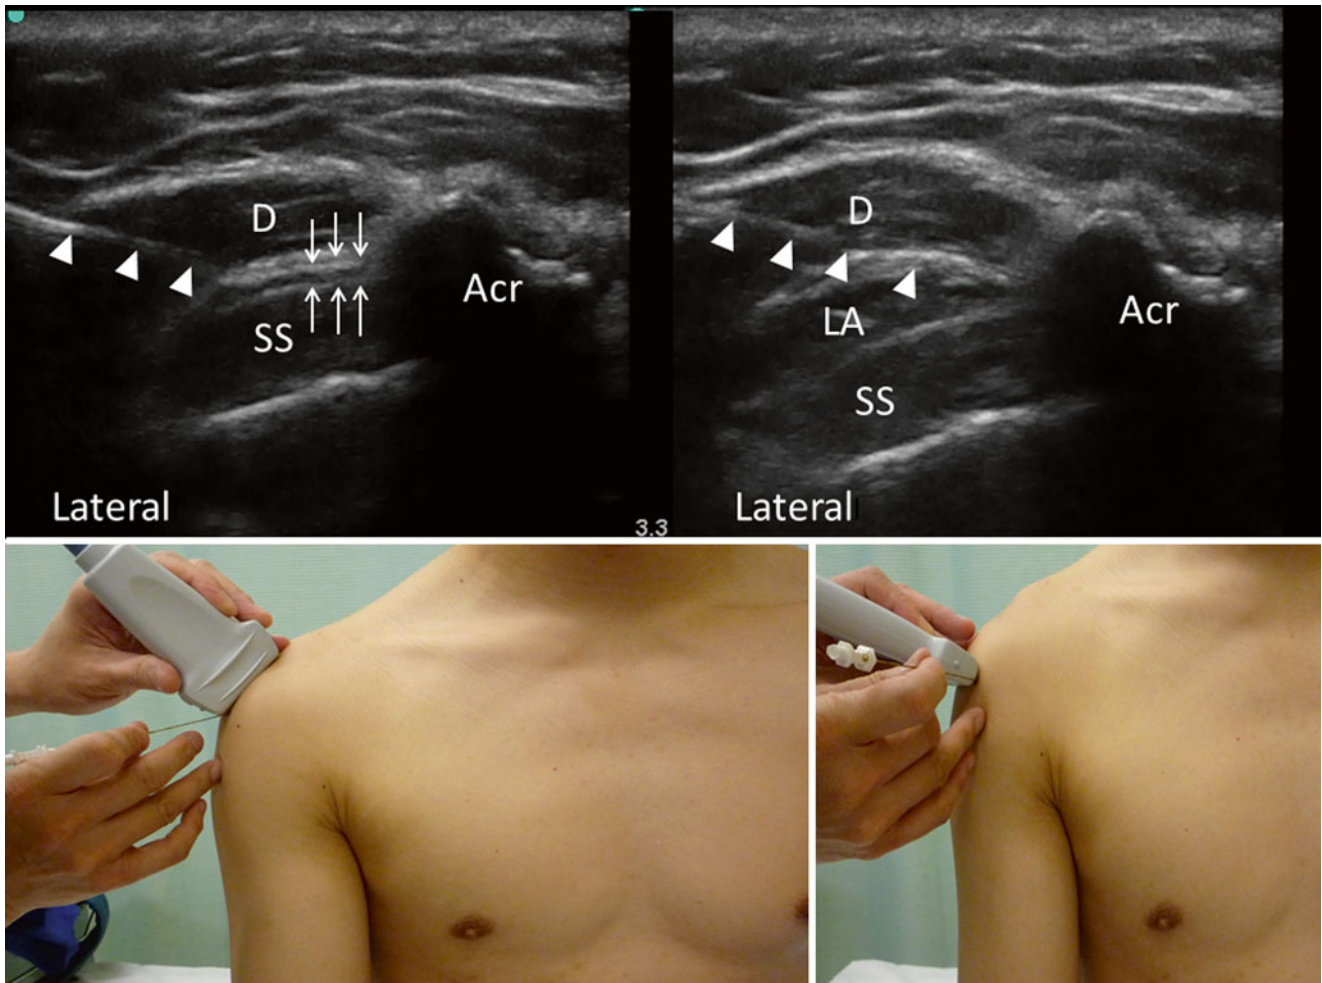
Ultrasound images of subacromial subdeltoid bursa (SASDB) injection. The top-left figure shows the needle (*arrowheads*) inserted with the in-plane technique to the SASDB, as highlighted by the peribursal fat (*line arrows*). The image on the top right shows the presence of local anesthetic (*LA*) following the injection, with the separation of the deltoid muscle (*D*) and supraspinatus tendon (*SS*). The
